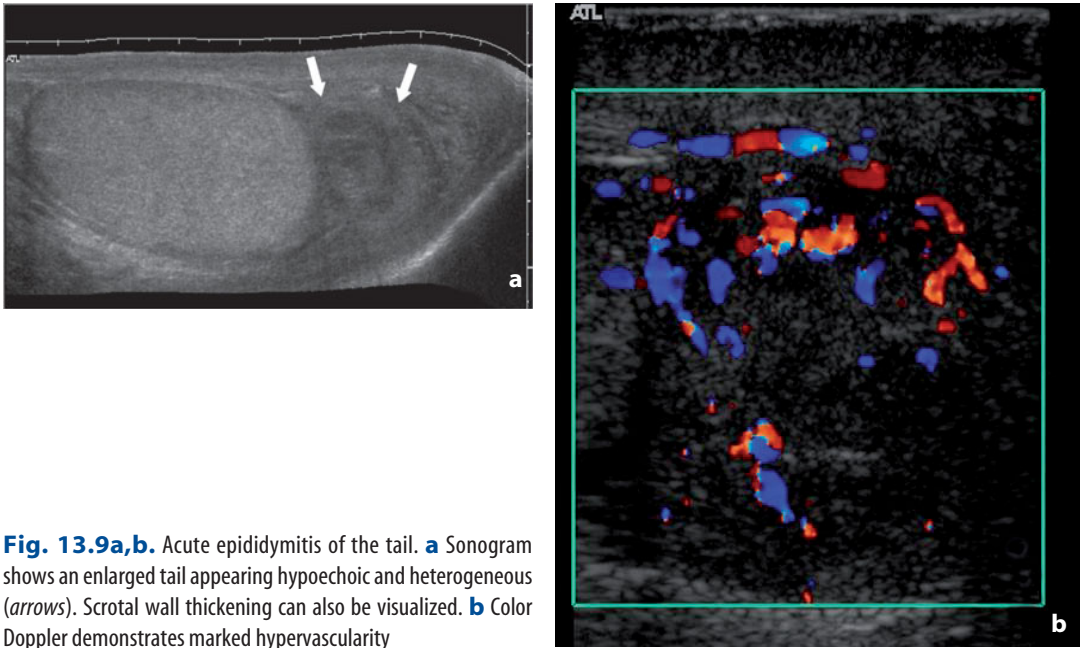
Acute epididymitis of the tail. a Sonogram shows an enlarged tail appearing hypoechoic and heterogeneous (*arrows*). Scrotal wall thickening can also be visualized. b Color Doppler demonstrates marked hypervascularity
